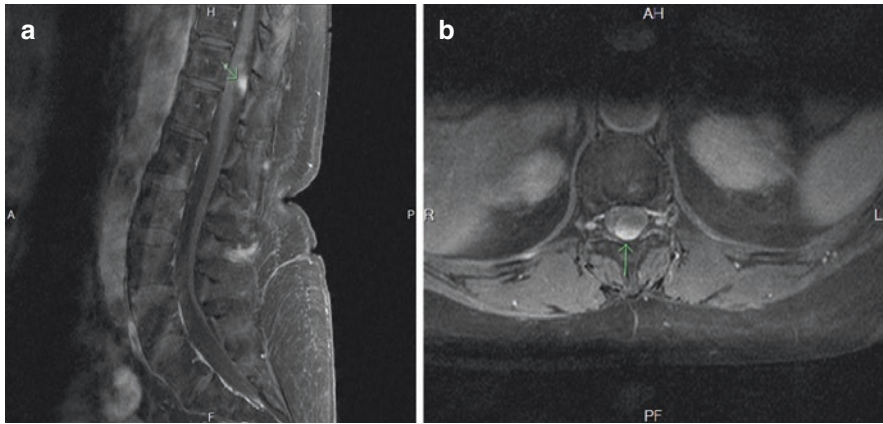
Lumbar spine T1-weighted MRI with contrast showing posterior midline intradural-extramedullary tumor compressing the conus medullaris. (a) Midline sagittal view. (b) Axial view at T12–L1 intervertebral disc level
